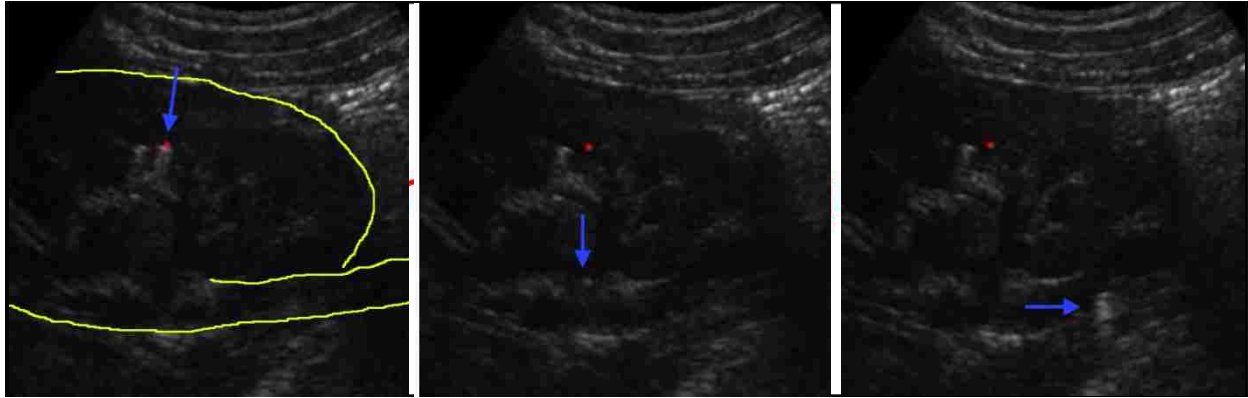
Real-time B-mode image of a stone pushed from the kidney. The blue arrow indicates the stone and direction of stone motion in the collecting system. After targeting (red dot), a single 0.5 sec. burst of ultrasound pulses is applied and the stone moves from the calyx to the ureter. All motion occurs in about 1 sec.
